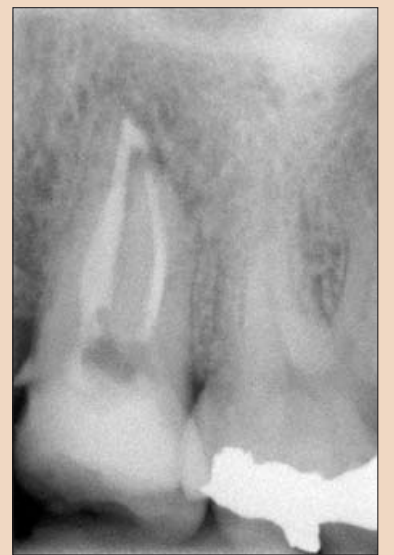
Coronal seal has been maintained allowing apical healing of periapical lesion one year following treatment. (Courtesy of Dr. Martin Trope).
